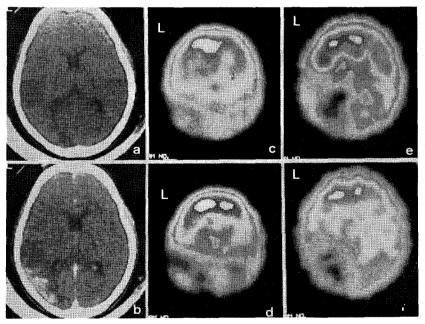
Brain CT before and after enhancement showing a large low density area with marked enhancement in left occipital lobe, but normal finding on right (a & b). Preoperative Tc-99m-HMPAO brain SPECT showing inhomogeneous perfusion defectin left parietooccipital lobe and homogeneous perfusion defect in right occipital lobe (c & d). Follow-up brain SPECT after right side bypass surgery showing moderate improvement of perfusion in right occipital lobe (e & f).
